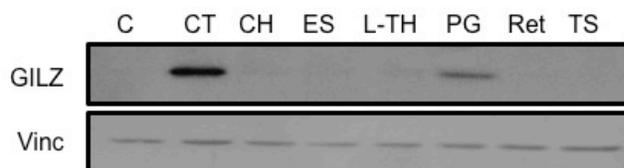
Western blot analysis of GILZ in the presence of corticosterone (CT), cholesterol (CH), estrogen (ES), L-Thyroxine (L-TH), progesterone (PG), retinoic acid (Ret) or testosterone (TS).
